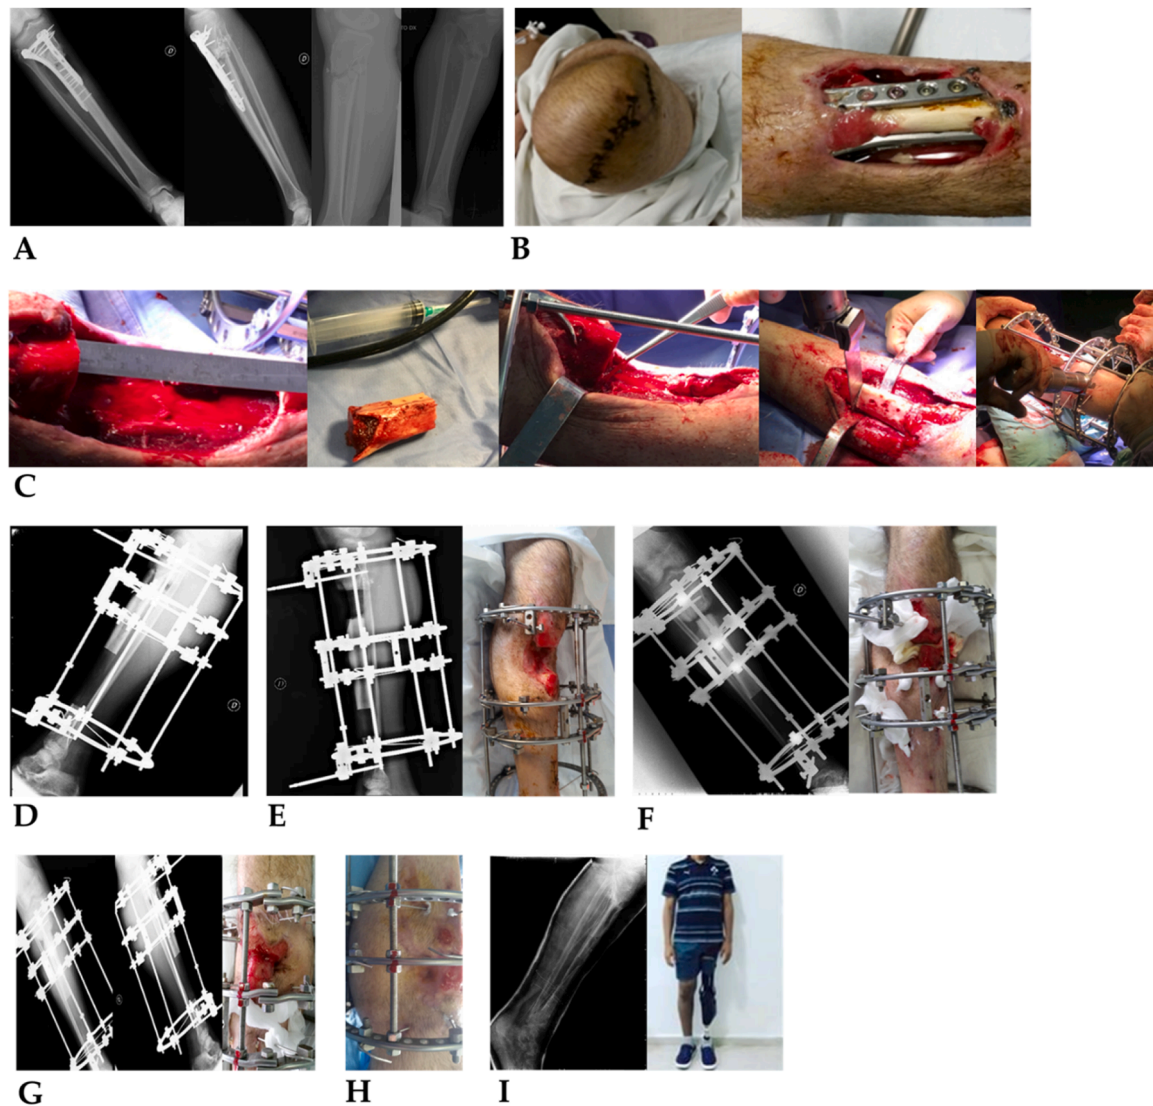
(A): reduction and synthesis with plates and screws at the proximal right tibia; (B): proximal III amputation of sinus leg at another hospital; (C): intra-operatively: pseudotumoral resection of necrotic bone and soft tissue and implantation of circular EF according to Ilizarov technique; (D): postoperative x-ray; (E): x-ray and clinical images during disto-proximal osteo-myotendinous transport (distal corticotomy); (F): x-ray after 6 months from the start of osteo-myotendinous transport; (G): x-ray after 7 months from the start of osteo-myotendinous transport; (H): re-epithelialization after docking-site compression; (I): x-ray and clinical re-evaluation after 1 year.
